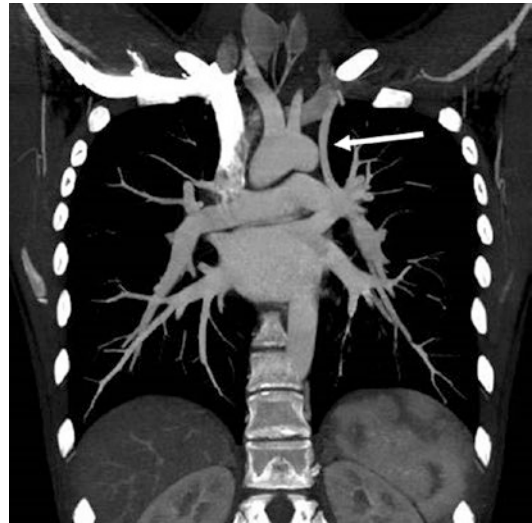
Levoatrial cardinal vein at CT angiography. Coronal thin maximum intensity projection image demonstrates a levoatrial cardinal vein (*white arrow*) connecting the left superior pulmonary vein to the left brachiocephalic vein. The left superior pulmonary vein drains also normally into left atrium
